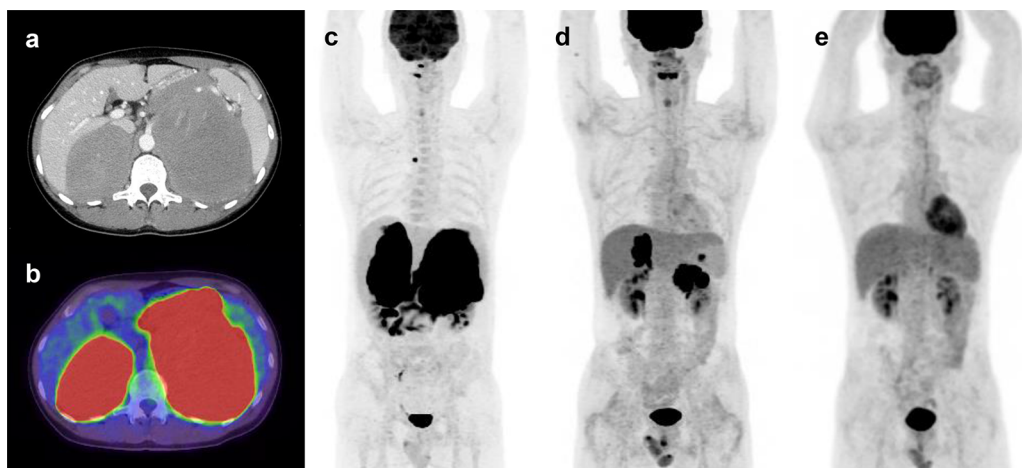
Radiological findings. At diagnosis, computed tomography (CT) (a) and Positron emission tomography (PET)/CT (b) revealed the presence of bilateral bulky adrenal tumors with direct invasion toward the pancreas. The maximum standardized uptake value (SUVmax) was high (left 23.1, right 24.0). PET (c) also revealed the presence of some other lesions that were not obvious in CT. Systemic relapse was detected 2 months post transplantation (d), and was well controlled after short-term administration of L-asparaginase (e).
